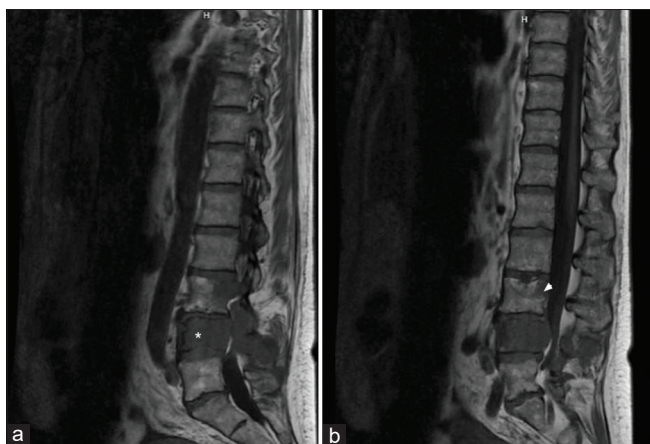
Sagittal magnetic resonance imaging of the lumbar spine demonstrating near-complete marrow replacement of the L4 vertebral body (*) with expansile, locally destructive soft tissue with extension into the left posterior elements and spinous process (a). Associated extra cortical extension of disease with circumferential encasement of the epidural space resulting in extremely severe spinal canal stenosis with compression of the cauda equina nerve roots. There is also replacement of the posterior aspect of the L3 vertebral body (arrow head) and associated 20 percent posterior pathological compression fracture deformity (b). Frank extra cortical disease extension at this level results in moderate spinal canal narrowing with asymmetric effacement of the left lateral recess and compression of the traversing left L4 nerve roots.
